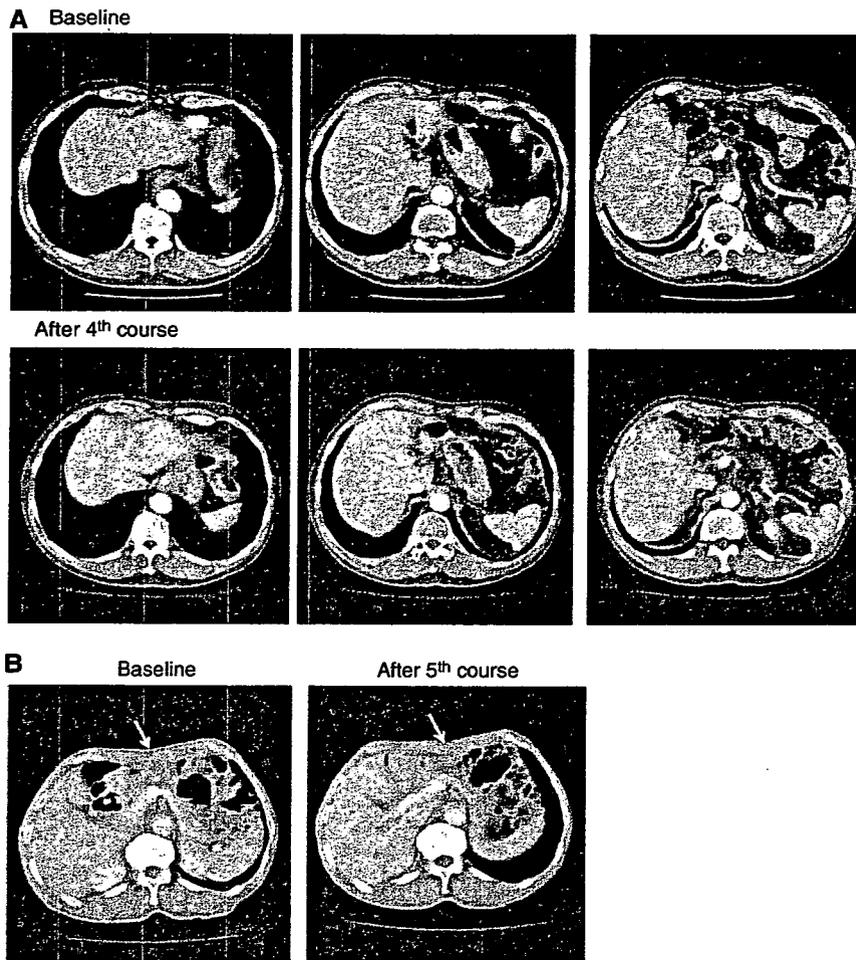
Serial CT scans. (A) A 60-year-old male with pancreatic cancer who was treated with NK105 at a dose level of 150 mg m^{-2} . Baseline scan (upper panels) showing multiple metastasis in the liver. Partial response, characterized by a more than 90% decrease in the size of the liver metastasis (lower panels) compared with the baseline scan. The antitumour response was maintained for nearly 1 year. (B) A 64-year-old male with stomach cancer who was treated with NK105 at a dose level of 150 mg m^{-2} . Baseline scan (left panel) showing a peritoneal metastasis and liver metastasis. About 40% reduction (right panel) was observed in peritoneal metastasis, but not in the liver metastasis after fifth course.
